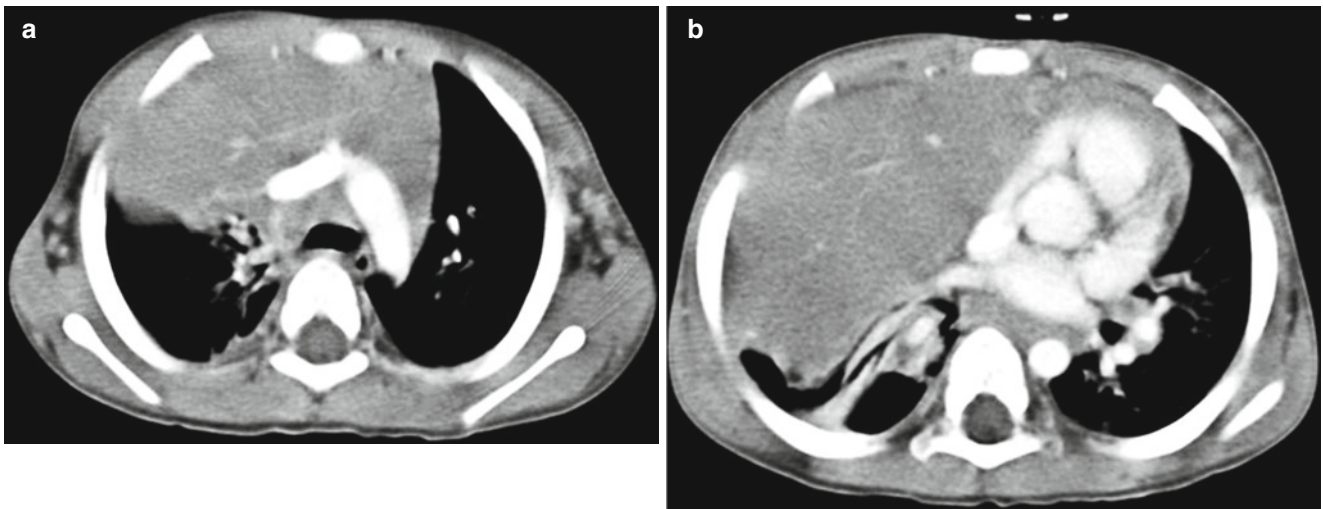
Non-Hodgkin's lymphoma in a 2-year-old boy with productive cough. (a, b) Contrast-enhanced CT shows an enlarged right thymic lobe. Small linear foci of enhancement represent thymic vessels.
